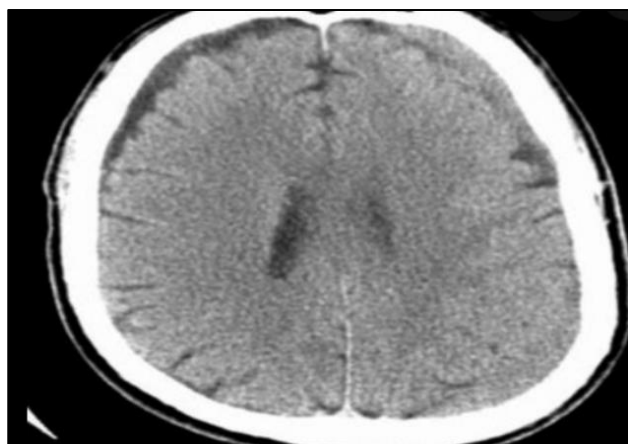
CT brain of SDH adjacent to fronto-parital region.
